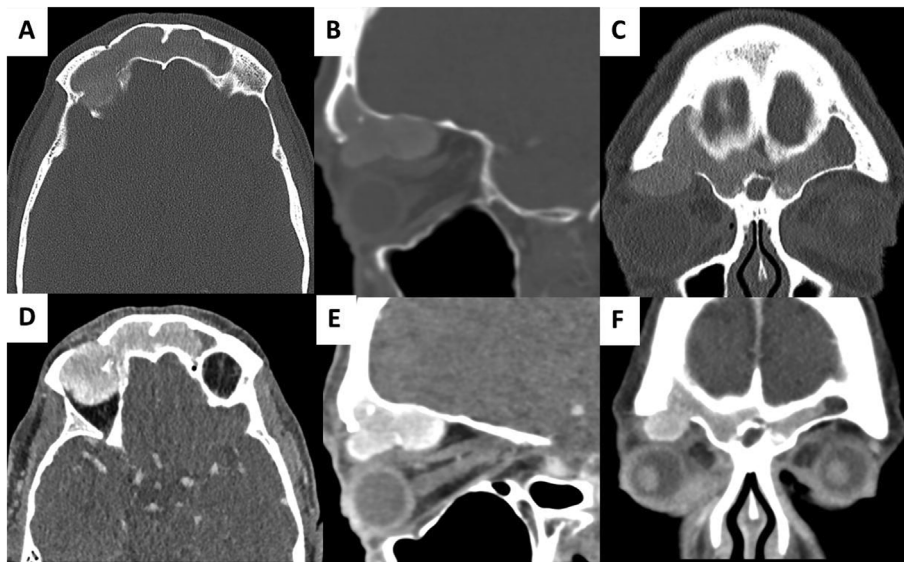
CT images in the axial (A,D), sagittal (B,E) and coronal (C,F) planes in bone window without contrast (top row) and in soft tissue window after contrast (bottom row).
